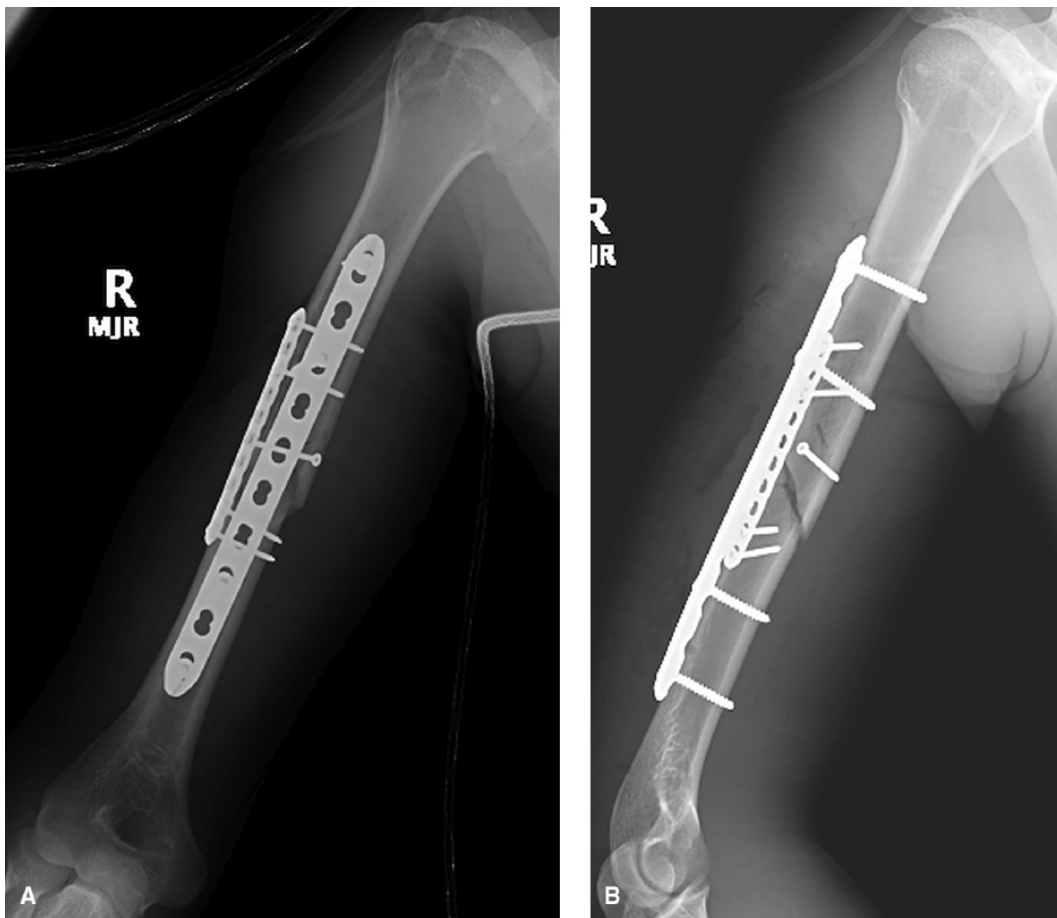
A and B: Postoperative radiographs.
